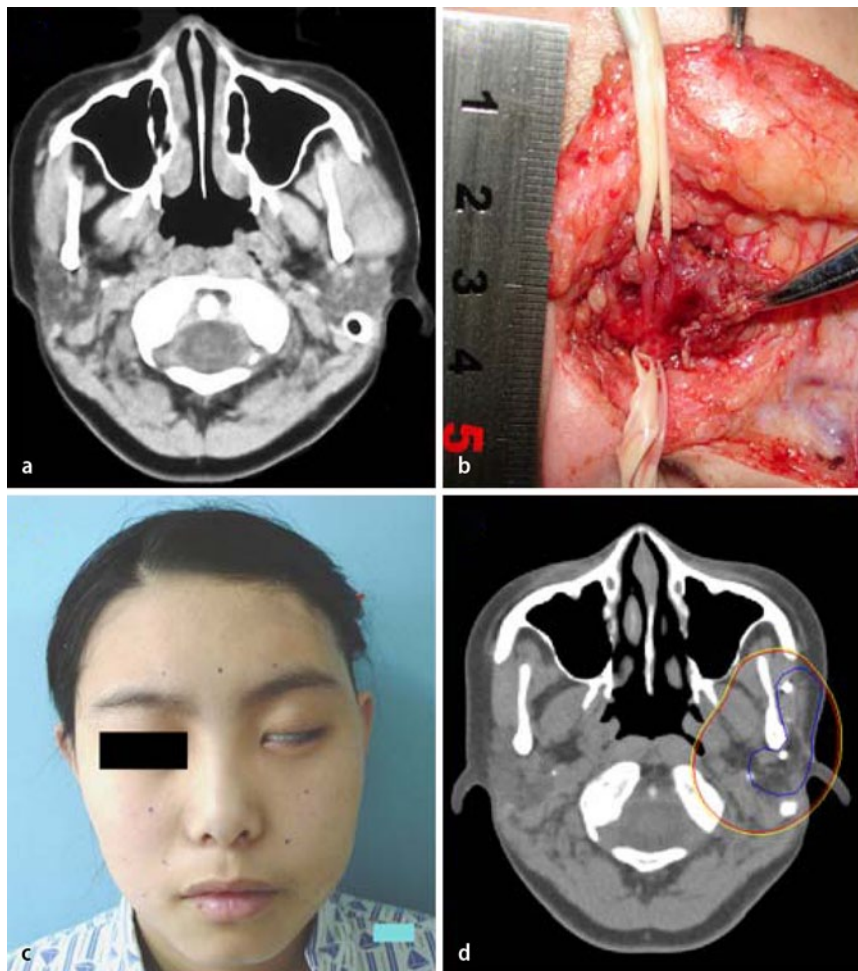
▲ a CT shows the tumor in the *left* parotid gland. b The buccal branches of facial nerve are adherent to the tumor. c This patient had incomplete eye closure 1 week postoperatively. d A typical transverse slice shows the distributions of the ^{125}I seeds and isodose curves of the patient underwent postoperative ^{125}I seed implant brachytherapy
